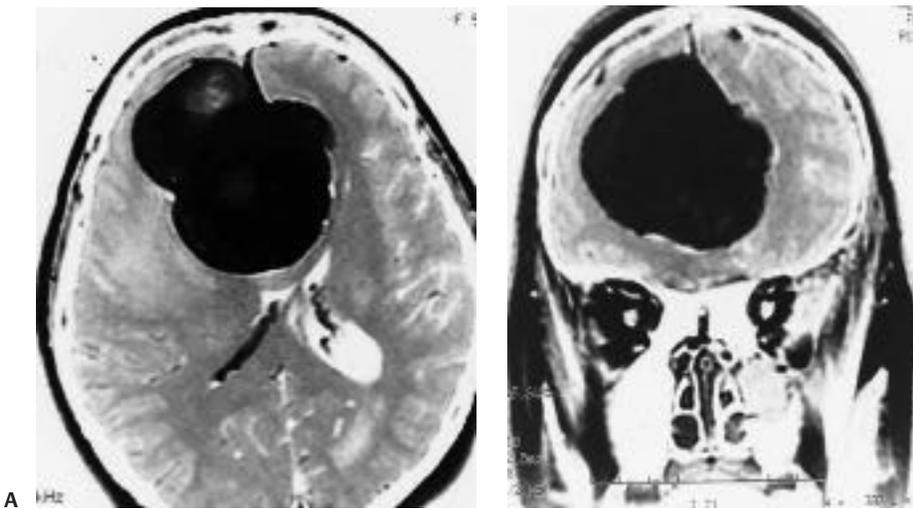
(A) Axial postcontrast T1-weighted magnetic resonance imaging (MRI). Huge anterior third falx meningioma. The vascular displacement of the pericallosal and callosomarginal arteries, identified as flow-voids at the edge of the tumor, are well seen. (B) Coronal post-contrast T1-weighted MRI. Note that the tumor is completely hidden by overlying cortex.
